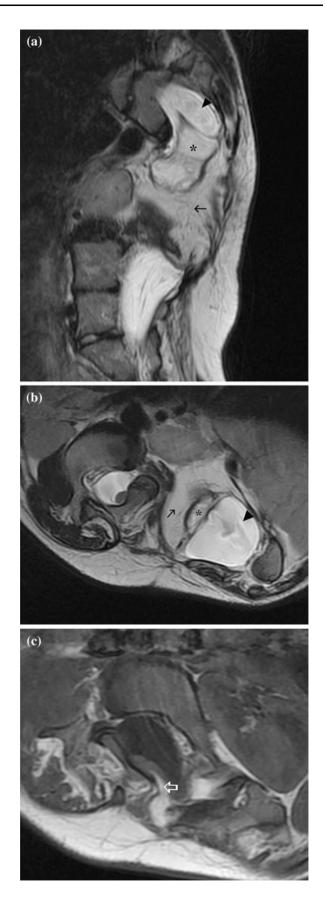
T2-weighted sagittal (a) and axial (b) MR images show the lipomyelomeningocele sac (*asterisk*) and surrounding fat (*arrow*) adjacent to the left-sided thecal sac (*arrowhead*). T1-weighted axial image (c) shows the fat tissue (*open arrow*) enters into the right sided thecal sac and adheres to the tethered spinal cord
